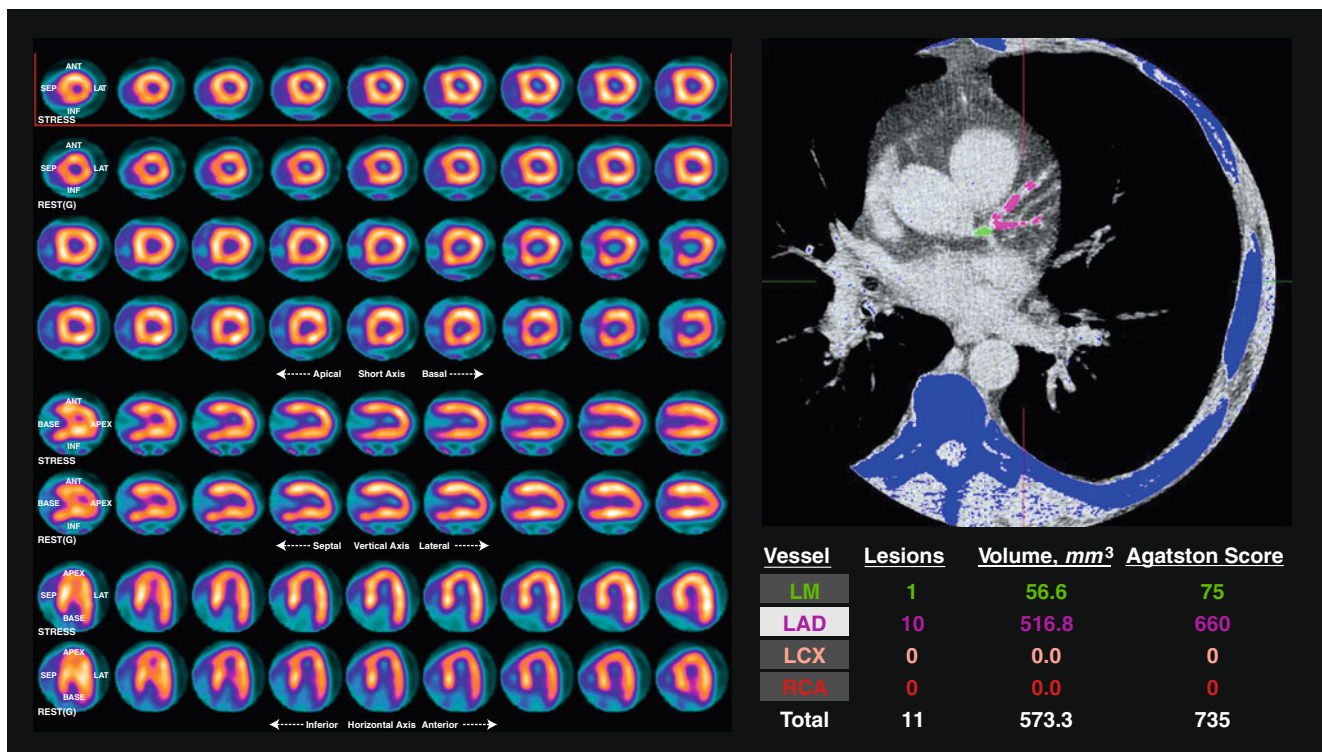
Static images of SPECT myocardial perfusion scintigraphy demonstrating normal myocardial perfusion indicate very low risk for cardiac events. Coronary calcium study revealed extensive calcified plaques in the left main (LM) and anterior descending (LAD) coronary
